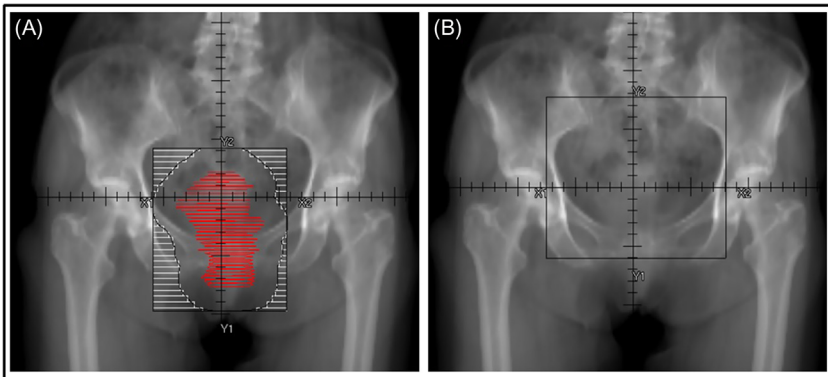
(A): Digitally reconstructed radiograph (DRR) of a patient with vaginal cancer with 3-dimensional contour of a gross tumor volume (GTV) and anteroposterior (AP) beam with 2 cm block margin. (B): AP X-ray for 2-dimensional planning with a 15 × 15 cm pelvic field for a patient with cervical cancer.
